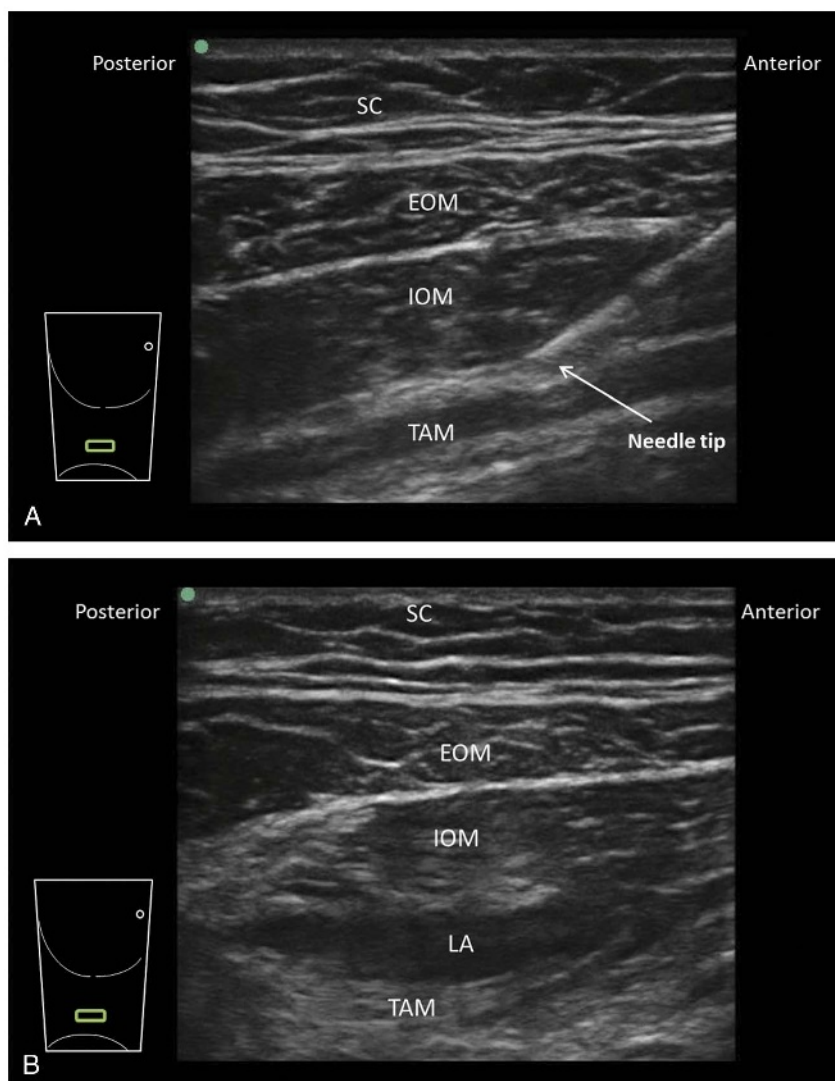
Ultrasound-guided lateral TAP block. A, Preinjection image. The US probe is placed in a transverse orientation between the costal margin and iliac crest in the midaxillary line. A needle is advanced in an anterior-to-posterior direction through the muscular layers of the abdominal wall to reach the TAP between IOM and TAM. The TAM has a characteristic darker hypoechoic appearance and is usually significantly thinner than the IOM. B, Postinjection image. Local anesthetic (LA) has distended the TAP, separating IOM and TAM. SC indicates subcutaneous tissue. Reproduced with permission from KJ Chin Medicine Professional Corporation.
